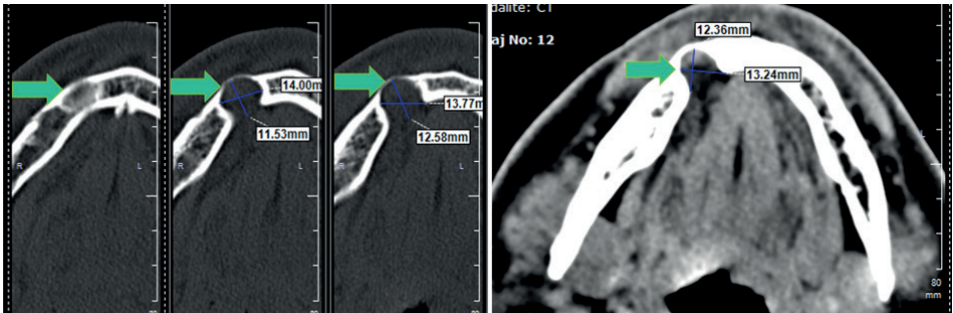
CT image taken at an external centre, two years before the first examination
